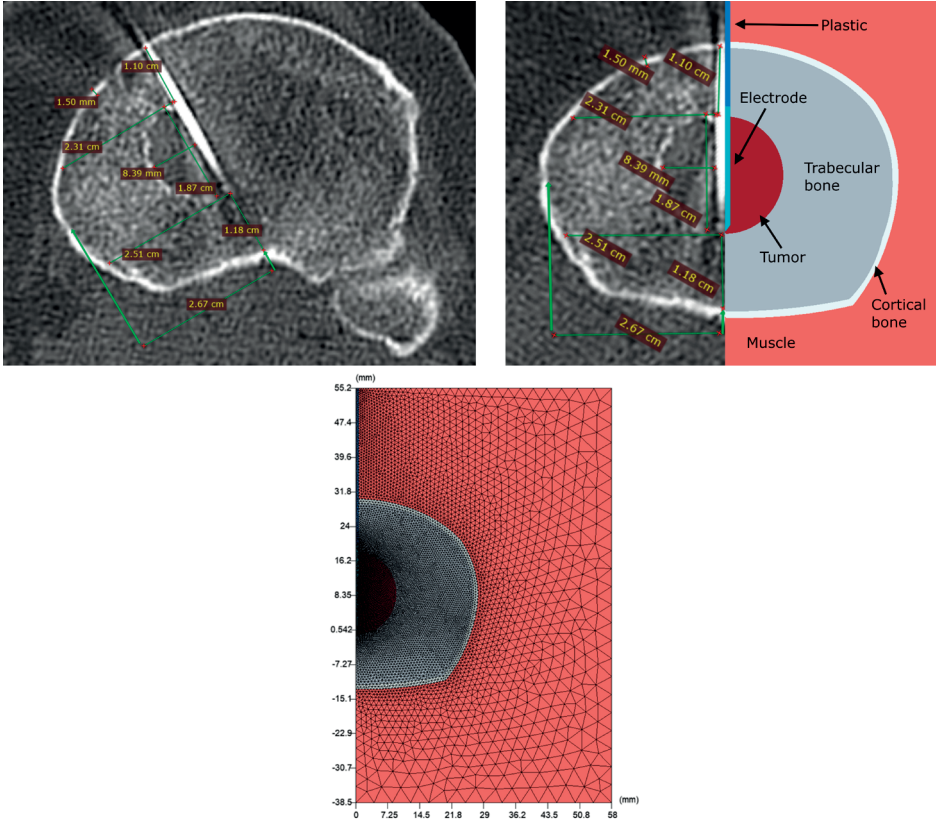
The top images show the intraoperative CT image with measurements of the tumor (a round hypodense focus around the electrode) and its spacial relation to its surroundings and how the electrode was used as axis of symmetry for the resulting axisymmetric model. The contrast window was adjusted from the previous figure to more clearly highlight the cortical bone and tumor. The bottom image shows the meshing of the model, having smaller elements next to the electrode-tumor interface, where more resolution is needed because of the higher gradients of current and temperature at the electrode and because of its smaller size.
